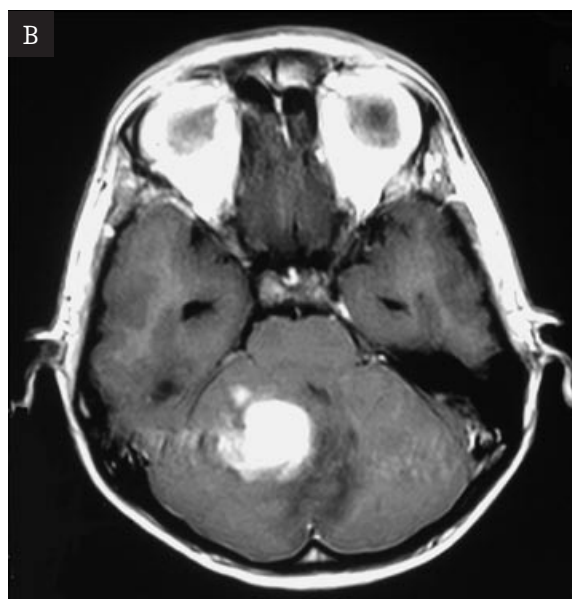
A metastatic lesion in the right cerebellar hemisphere after resection of the fourth ventricle ependymoma. Axial T2-weighted (A) and T1-weighted after paramagnetic contrast administration (B) image. Heterogeneous tumor displacing the right cerebellar hemisphere.
